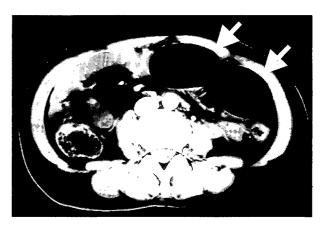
Contrast enhanced CT showing the double-dilated sigmoid colon (arrows).
